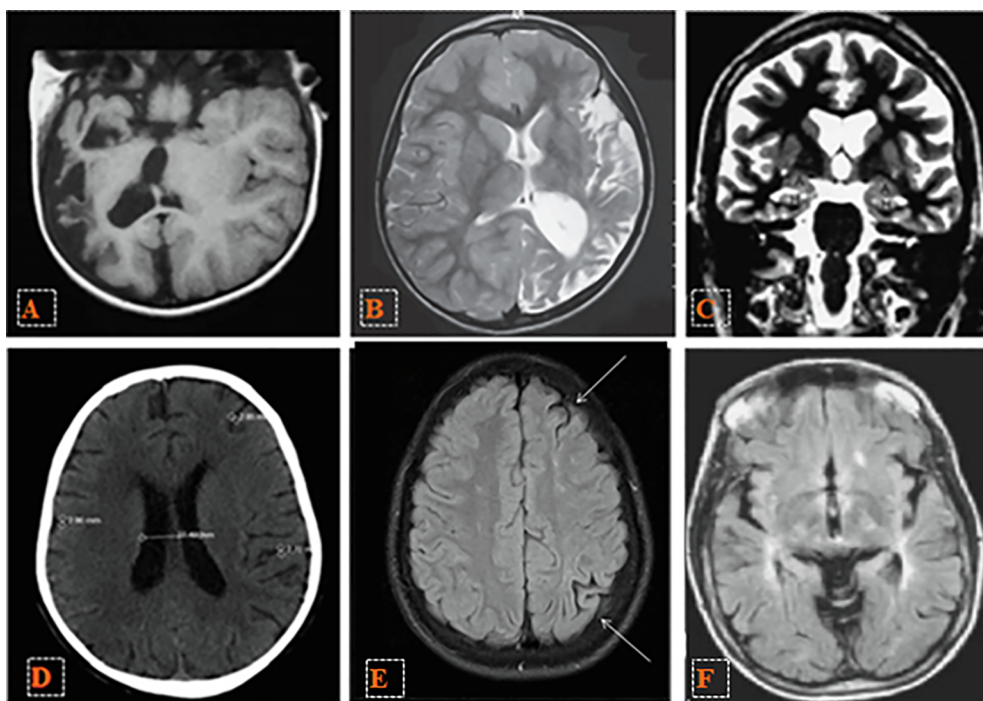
Types of brain atrophy. A: Right brain hemiatrophy on MRI [37], B: Left brain hemiatrophy in nine years girl MRI image [41] C: Global brain atrophy in T2-coronal MRI showing involvement of hippocampus and amygdala [42] D: Cortical brain atrophy evidenced by widening of sulci > 2.5 mm in a pediatric patient on CT image [43], E: Focal or regional atrophy in the left frontal and parietal occipital lobes on MRI [44] F: Central type of brain atrophy, well measured in multiple sclerosis patient showing enlarged 3rd ventricle per age [45].
